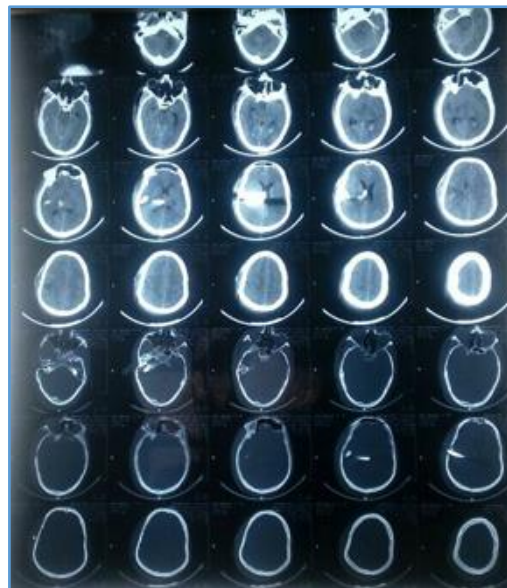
CT Scan Film of Brain
